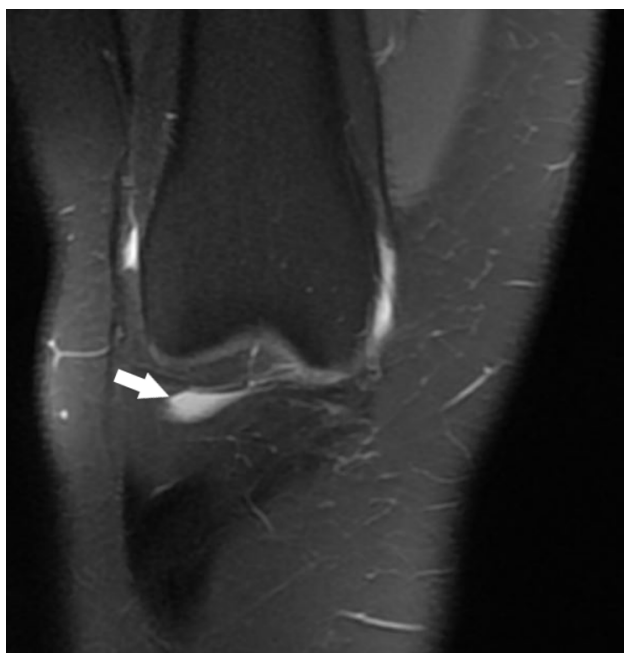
MR image (coronal PD with fat suppression) White arrow: Infrapatellar cyst
